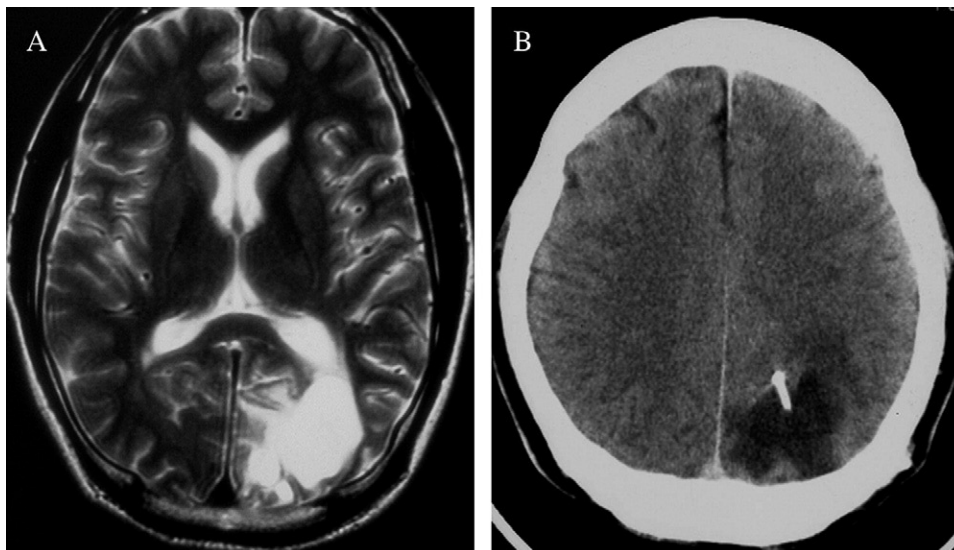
Delayed cyst formation after radiosurgery of left parietooccipital AVM (case 1): T₂-weighted MRI at the time of clinical manifestation (A) and follow-up CT after cyst-peritoneal shunting (B).
